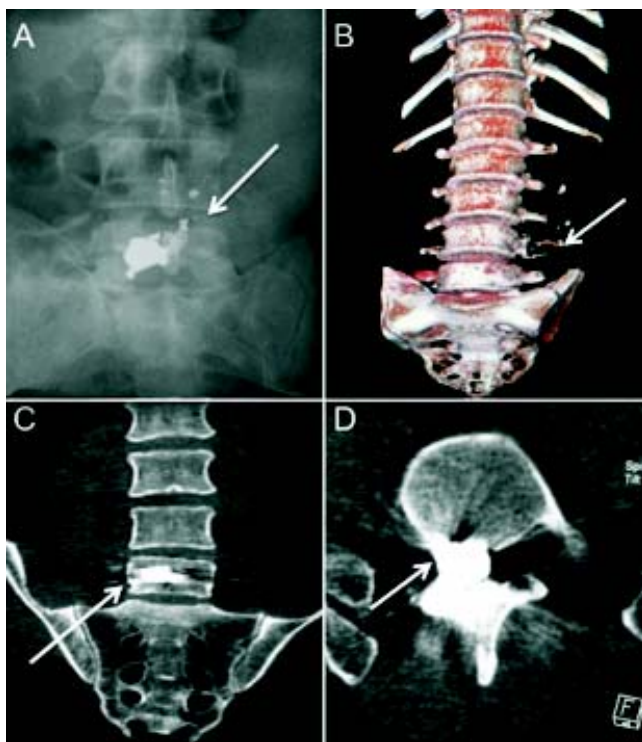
A. Lumbosacral AP plain film depicting a firearm bullet at the L5 level. B. 3D CT reconstruction showing in AP view destruction of the left transverse process of L4 (suggesting direction of the gunshot, white arrow). C and D. Coronal and axial plane images of CT showing the increased signal density corresponding with the fire arm bullet (white arrows).
